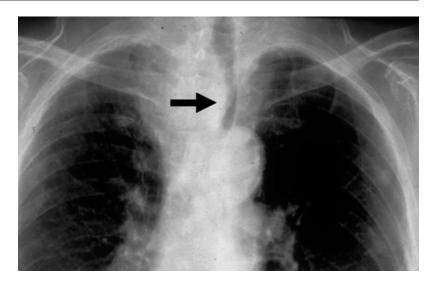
Plain X-ray showing calcification in a retrosternal goiter with right tracheal deviation
